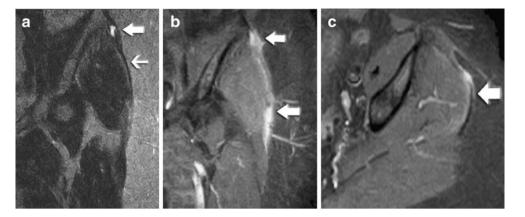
Coronal T2-weighted (a), coronal STIR (b), and axial STIR (c) images obtained using an open 0.3 T MRI through the left hip and hemipelvis in a 67-year-old female with nontraumatic onset of pain. a An intrasubstance partial thickness tear at the iliac tubercle enthesis of the ITB (*bold arrow*), which is clearly contiguous with the ITB more
